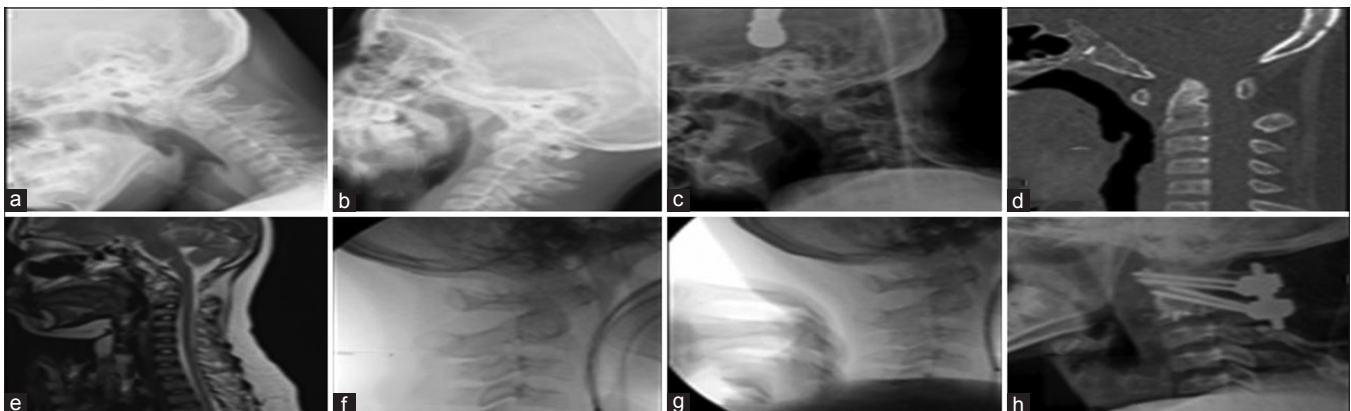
Case 1 atlantoaxial dislocation (AAD) without fracture: (a) preoperative X-ray showing irreducible AAD in flexion, (b) preoperative X-ray showing irreducible AAD in extension, (c) post-traction X-ray showing irreducible AAD, (d) midsagittal computed tomography spine showing AAD with canal narrowing, (e) Magnetic Resonance Imaging cervical spine showing AAD at C1 with obliteration of anterior CSF spaces, (f) intraoperative X-ray after positioning under general anesthesia before thumb maneuver showing AAD, (g) intraoperative X-ray after positioning under general anesthesia after thumb maneuver showing reduction of AAD, (h) postoperative implant *in situ* with reduction of AAD
